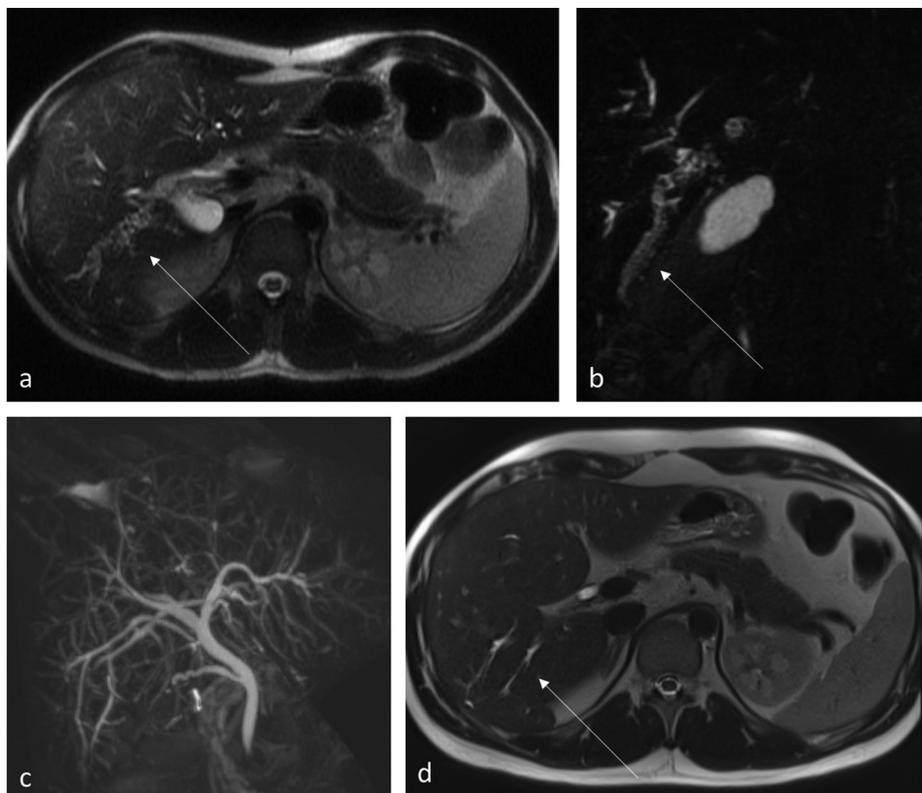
Remarkable evolution with ursodeoxycholic acid; a: MRI in T2 Haste sequence, axial section: stones in the posterolateral sector (arrow); b: MRI 3D-Bili sequence, coronal reconstruction: stones in the posterolateral sector (arrow); c: coronal reconstruction MIP Bili-RM 3D following six months of treatment with ursodeoxycholic acid: complete disappearance of biliary tract stones in the posterolateral sector; d: MRI in T2 Haste sequence, axial section: disappearance of the stones in the posterolateral sector (arrow). Patient cholecystectomized at the age of 20. Recurrent angiocholitis episodes led to discovery of biliary tract stones in the posterolateral sector, which were treated ineffectively by several sphincterotomies and biliary endoprosthesis. Highlighting of an ABCB4/MDR3 mutation at the age of 22 prompted initiation of an ursodeoxycholic acid treatment that was remarkably effective, with symptom improvement in a few weeks and normalized imagery in 6 months.
